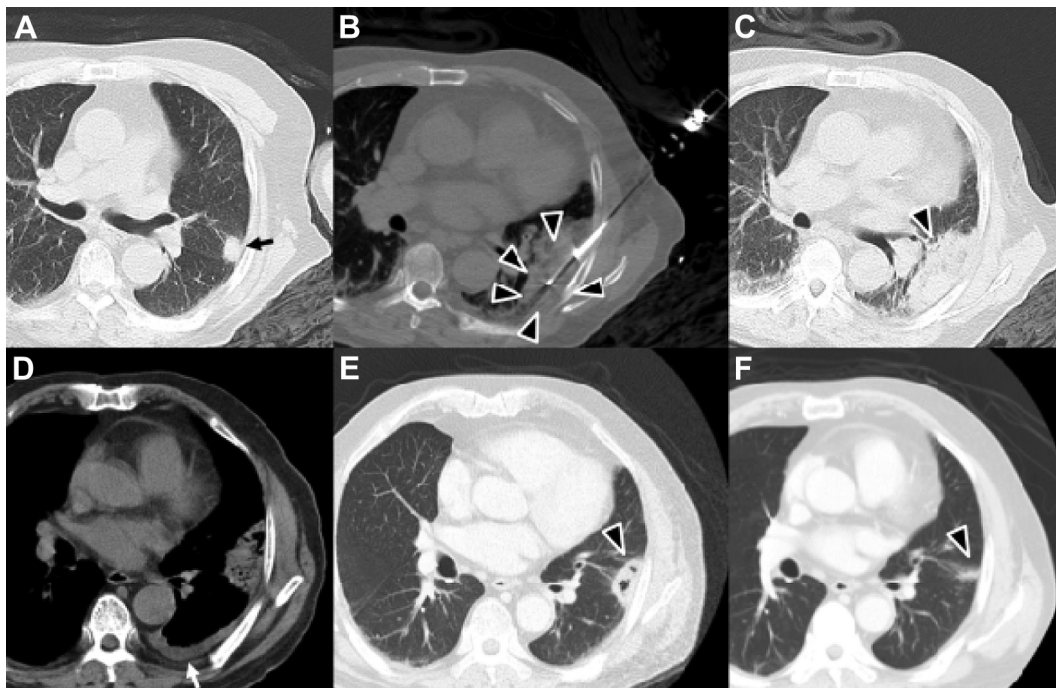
Images of squamous cell carcinomas in an 83-year-old male. (A) A preprocedural axial chest computed tomography (CT) image showed a nodule at the left upper lobe (arrow). (B) An image during the freezing phase of the ablation cycle showed a low-density elliptical ice ball, which is unique to cryoablation (compared to other modalities), covering the lesion (arrowheads). (C) The ablation zone is estimated by the consolidation rather than the ground glass surrounding the lesion. (D) Three days after the procedure, pleural effusion (arrow) was observed, which is a common finding in cryoablation for subpleural lesions. (E) The ablation zone (arrowhead) showed involution with cavitation at 8 months after the procedure. (F) The CT at 12 months after the procedure showed further involution of the ablation zone (arrowhead).
